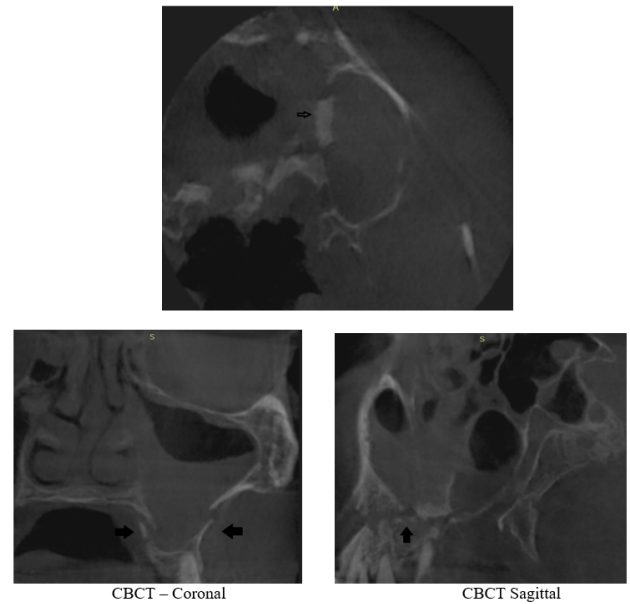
CBCT image - Axial
